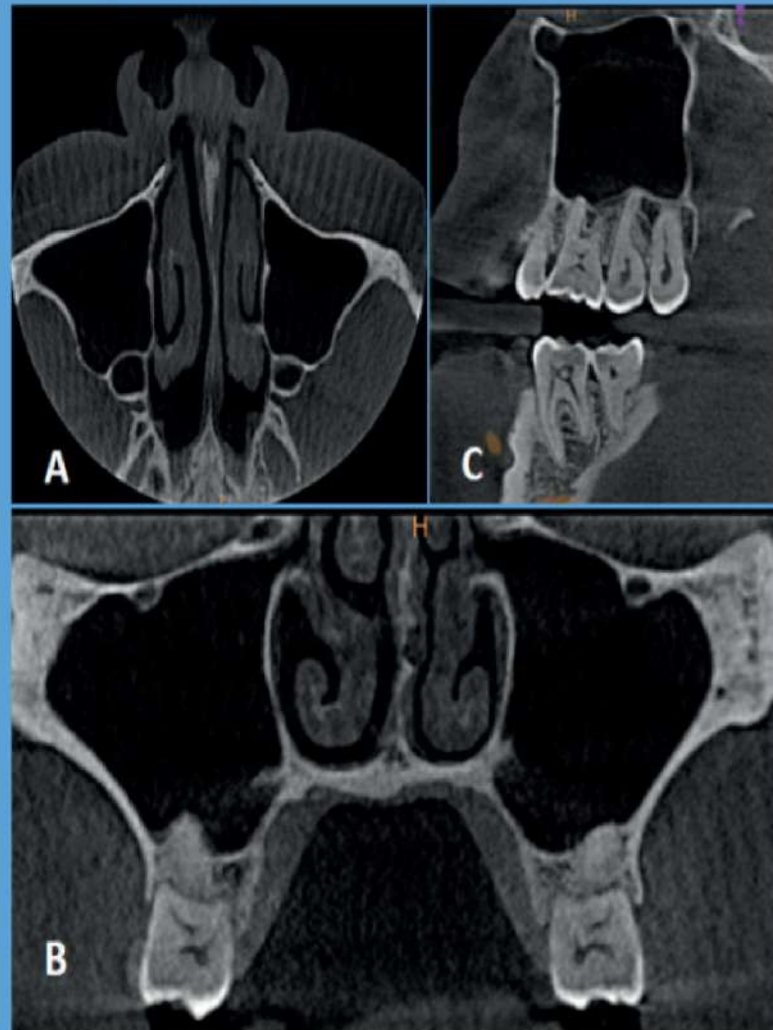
ENT applications of CBCT: MPR can be used for evaluation of paranasal air sinuses. Mild deviation of the nasal septum towards left side can be appreciated in the present scan along with other features of maxillary sinus
